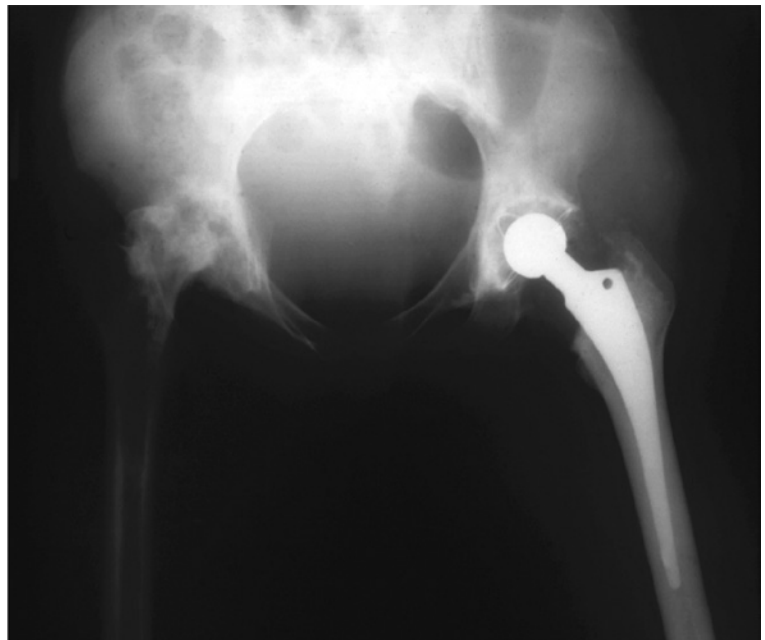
Radiograph of hips and pelvis in a patient with sickle cell/haemoglobin C compound heterozygosity showing osteonecrosis of one hip resulting from vascular occlusion by sickle cells; the other hip has already been replaced because of the same process. (With thanks to Professor Irene Roberts.)
